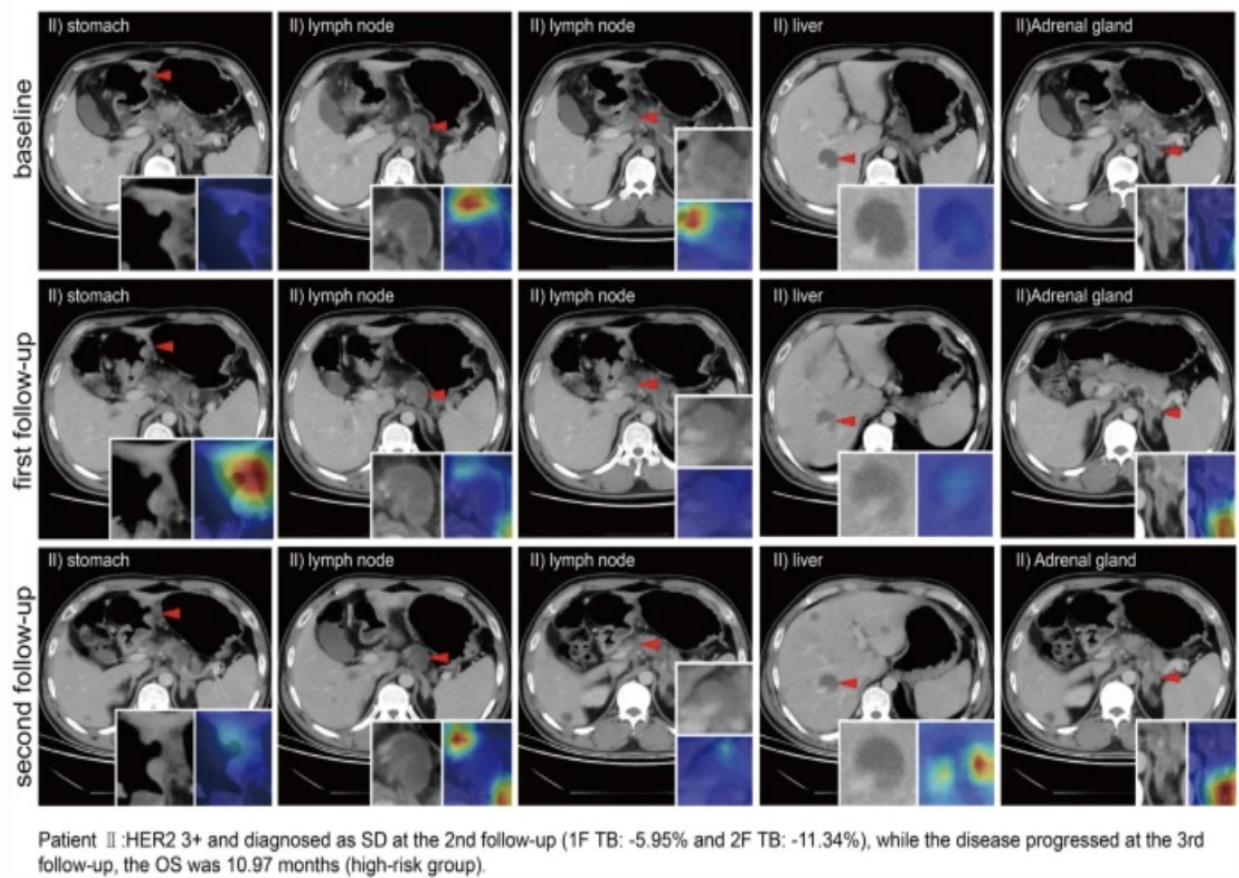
it shows how a ML model applied GRad-CAM visualization to highlight critical tumor regions from CT scans image. This model closely matches to label all known lesion areas and varies across different stages, can help doctors to track disease progression and make predictions (He et al., 2024).
